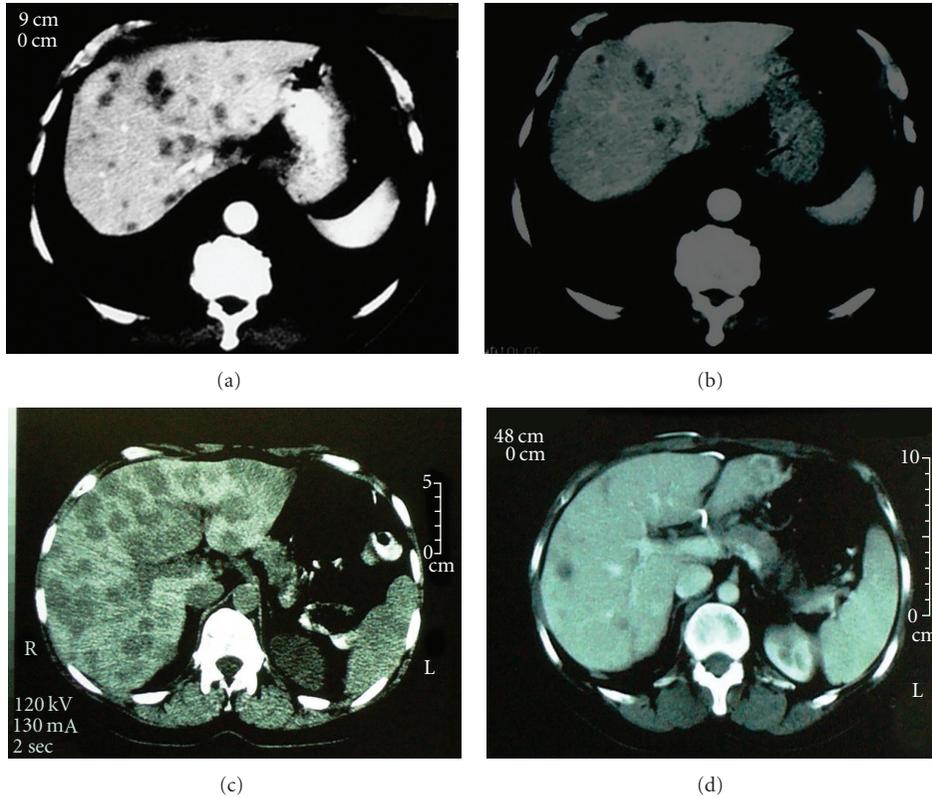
CT scans before and after SIRT. (a) patient 4 prior to SIRT, (b) patient 4 four years following SIRT, (c) patient 6 prior to SIRT, (d) patient 6 three months following SIRT.
